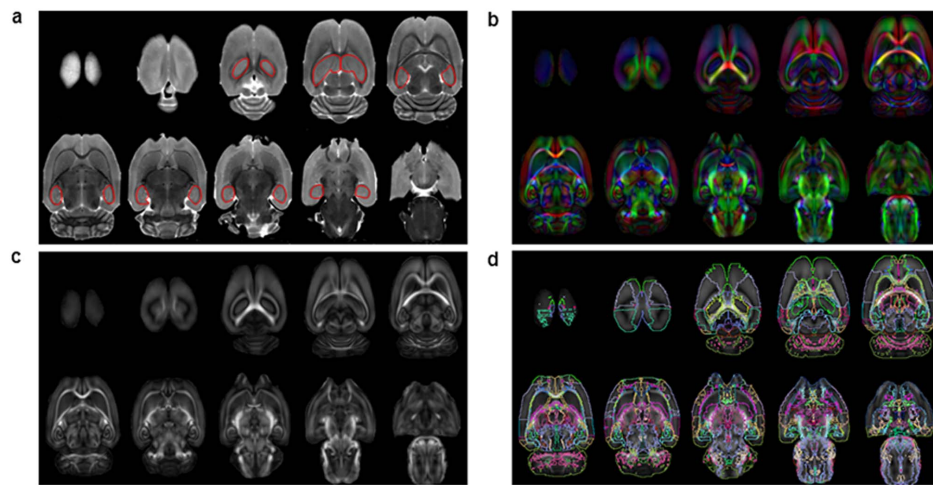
MRI data analysis. (a) A T2-weighted image from a single subject with the hippocampus manually outlined in red. (b) A mean directionally encoded color image. (c) Map of FA derived from DTI of all spatially registered brains (every second slice is shown). (d) The registered anatomical ROIs derived from the atlas overlaid on the FA map for visualization.
